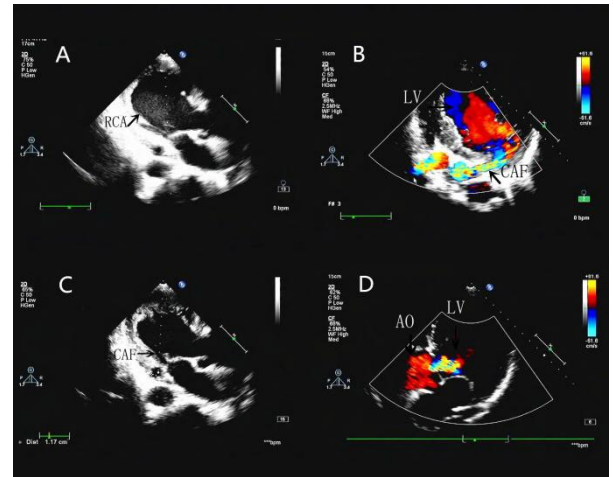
Transthoracic echocardiography (A): Aneurysmal dilatation of the proximal RCA (arrow) is 55mm. (B): the dilated tortuous RCA (arrow), CAF draining into the LV, (C): the diameter is 11.7mm (arrow) (D): aortic regurgitation
